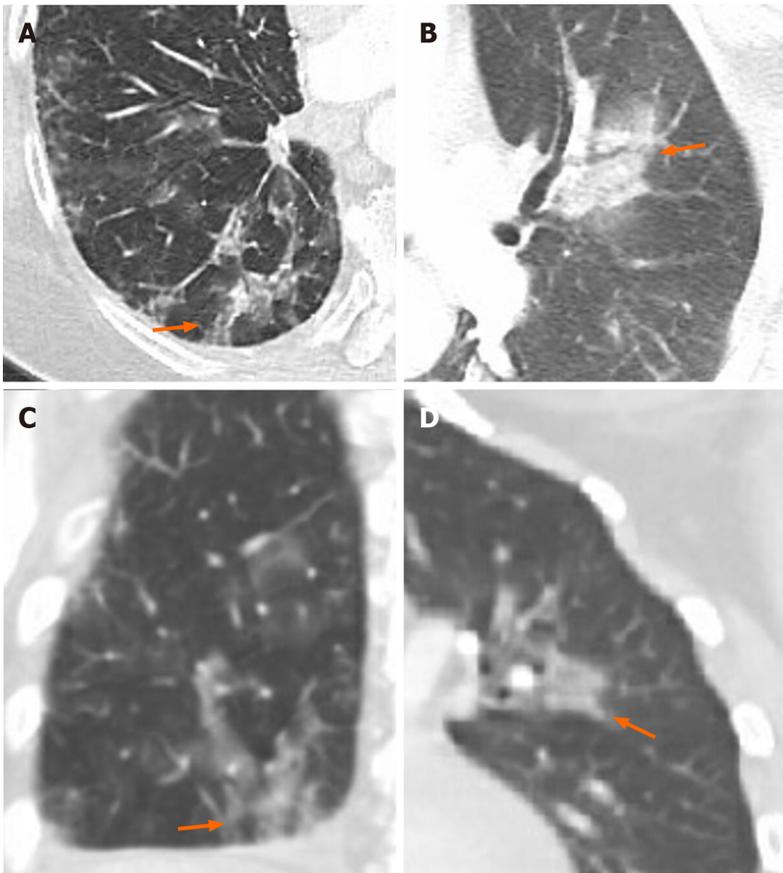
Multifocal patchy peribronchovascular ground glass to consolidative opacities in both lung parenchymas (orange arrows) in enlarged axial (A and B) and coronal (C and D) computed tomography chest in lung window.
